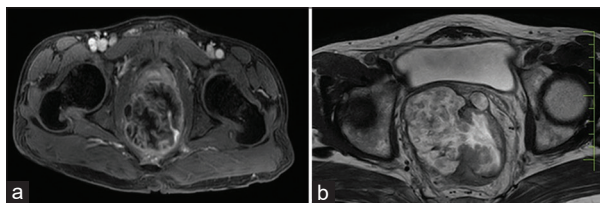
Magnetic resonance imaging axial hyperintense T2 weighted image of the rectum
